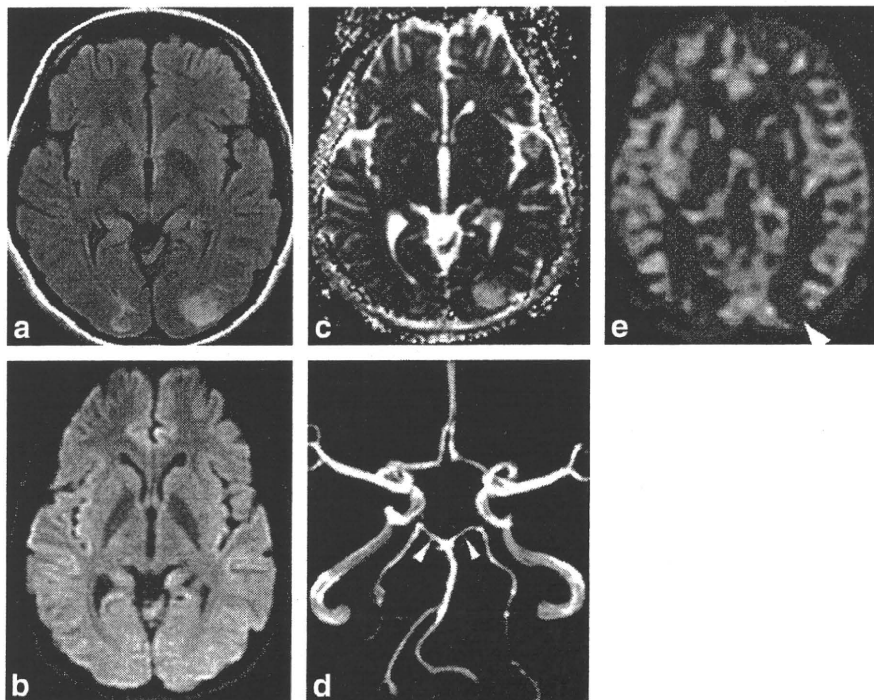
FLAIR imaging (GE-Signa 3.0 T, repetition time/echo time: 10002/121.3) on MRI detected high intensity signals in the occipital lobes with left side dominance (a). Diffusion weighted imaging (repetition time/echo time: 6000/64.6) showed an iso-intense signal (b). However, increase in the apparent diffusion coefficient (c) was observed, indicating vasogenic, rather than cytogenic edema. These findings were compatible with posterior reversible encephalopathy syndrome. MRA showed vasoconstriction of the posterior cerebral arteries (d: arrow). Continuous arterial spin labeling (CASL) perfusion images detected hypo-perfused regions in the bilateral occipital lobes with left side dominance (e: arrow).
